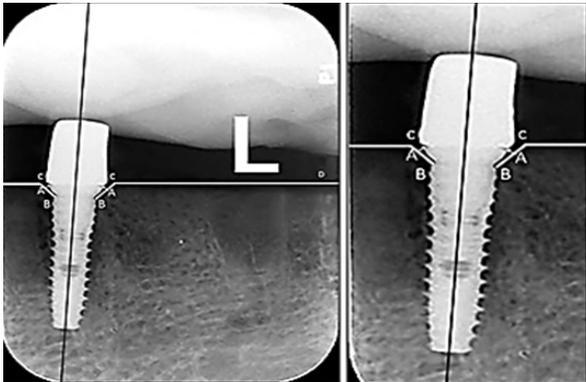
Traced periapical radiograph.
